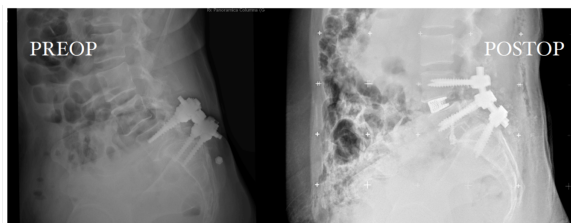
Left image represent preoperative Xr-ay and right image postoperative X-ray.
